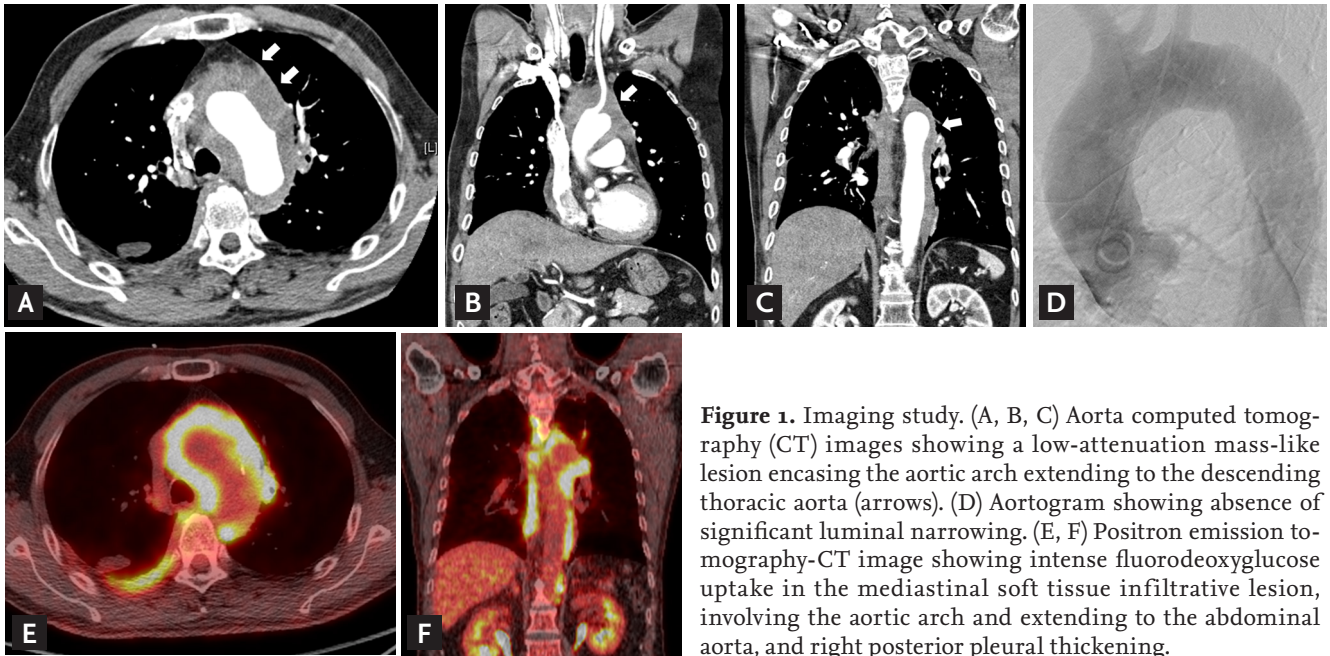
Imaging study. (A, B, C) Aorta computed tomography (CT) images showing a low-attenuation mass-like lesion encasing the aortic arch extending to the descending thoracic aorta (arrows). (D) Aortogram showing absence of significant luminal narrowing. (E, F) Positron emission tomography-CT image showing intense fluorodeoxyglucose uptake in the mediastinal soft tissue infiltrative lesion, involving the aortic arch and extending to the abdominal aorta, and right posterior pleural thickening.
